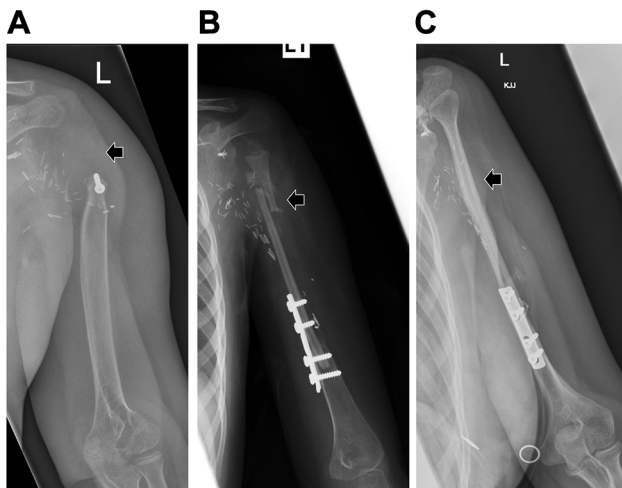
Representative complication radiographs. (A) Avascular necrosis of the fibula postoperatively. (B) The vascularized fibular epiphyseal transfer had a postoperative fracture, improving bone union in six months. (C) Radiographs are from the same patients' final follow-up as in (B).
